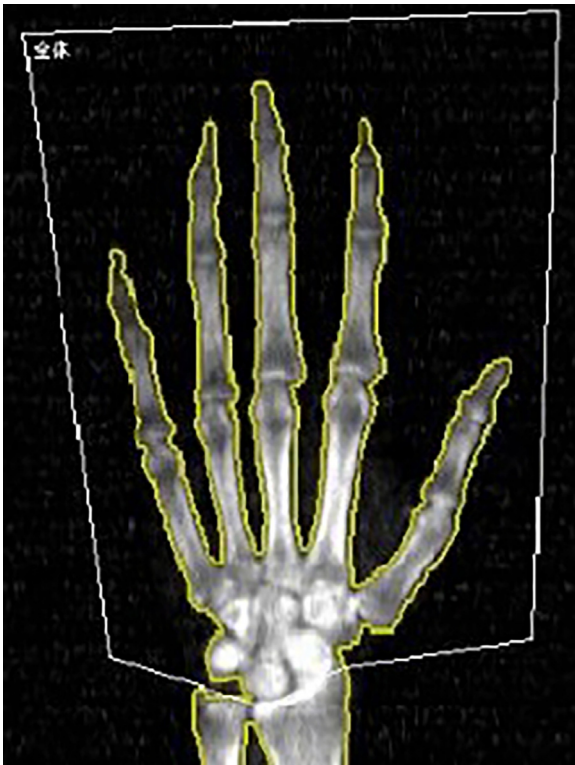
The measurement range of the hand BMD by DXA. BMD: bone mineral density, DXA: dual-energy x-ray absorptiometry
